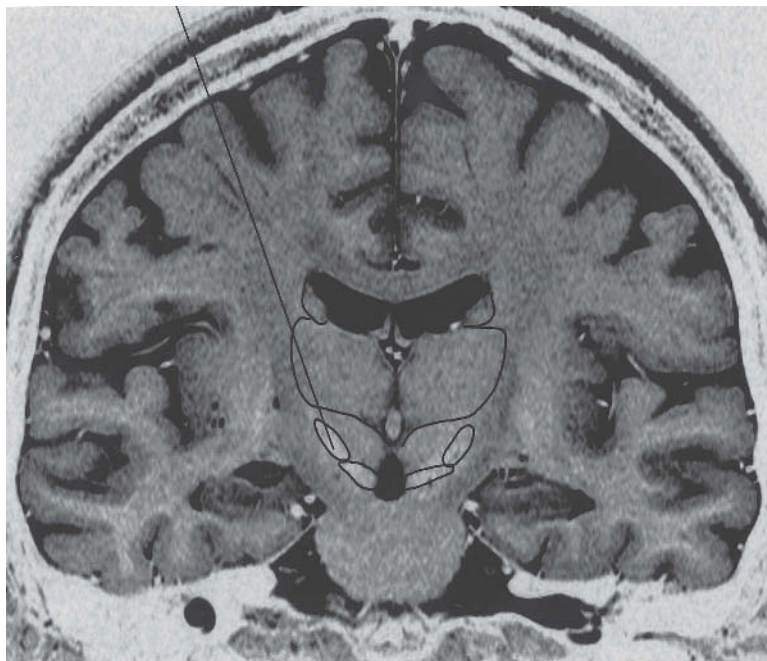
Inverted coronal T2 weighted MRI scan showing pre-operative planned trajectory.
